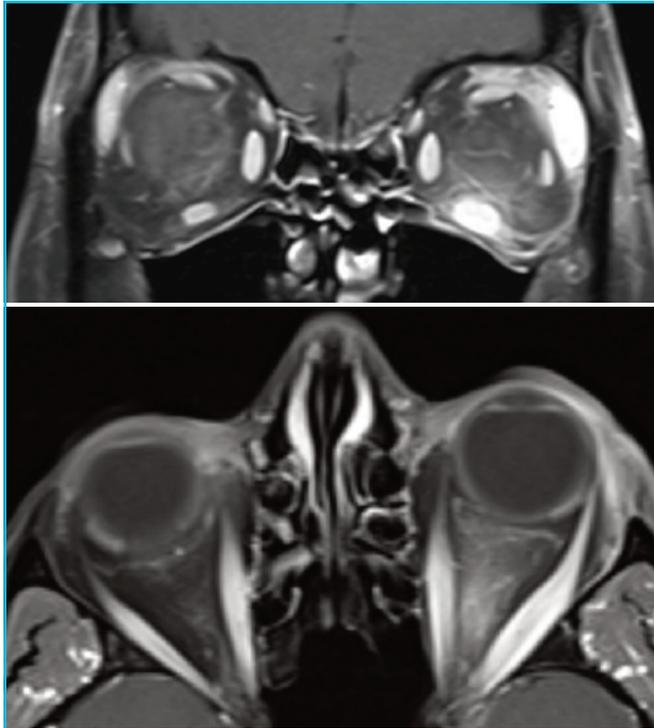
Magnetic resonance images showing left-sided proptosis of the patient presented in the Case
